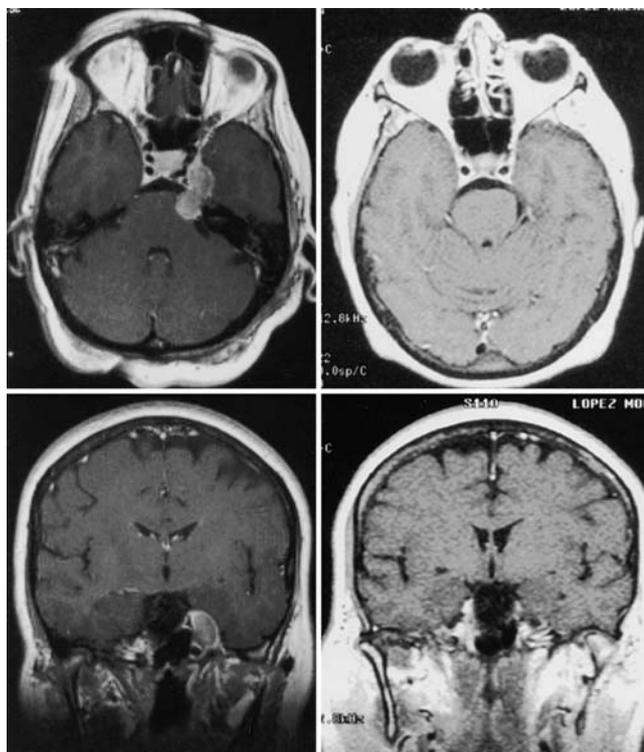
Axial (*upper left*) and coronal (*lower left*) postcontrast T<sub>1</sub>-weighted MR images obtained in a 50-year-old woman, demonstrating a metastatic melanoma measuring 3.83 cm<sup>3</sup> in volume in the left cavernous sinus, with extension to the Meckel cave and the prepontine cistern. Follow-up contrast-enhanced T<sub>1</sub>-weighted axial (*upper right*) and coronal (*lower right*) MR images obtained 7 years later, demonstrating no evidence of residual tumor. The lesion was not visible after the 12-month follow-up studies. The patient is in good health and is working full time at her usual occupation.
